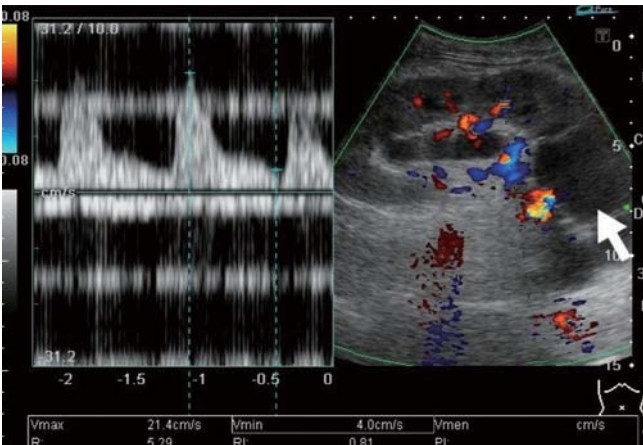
A typical case of lymphocele following renal transplantation. The low pole cystic mass (white arrow) compressed the ureter and caused hydronephrosis. In addition, note the calculated resistant index of renal arterial flow was high as 0.81 in the sonographic doppler scan.
